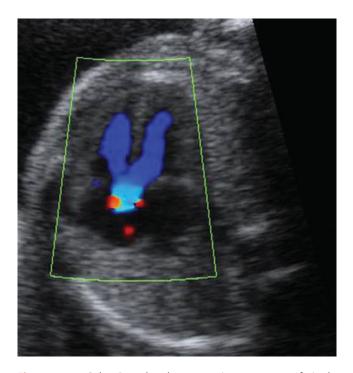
Color Doppler demonstrating presence of single large outflow tract consistent with a diagnosis of truncus arteriosus.
